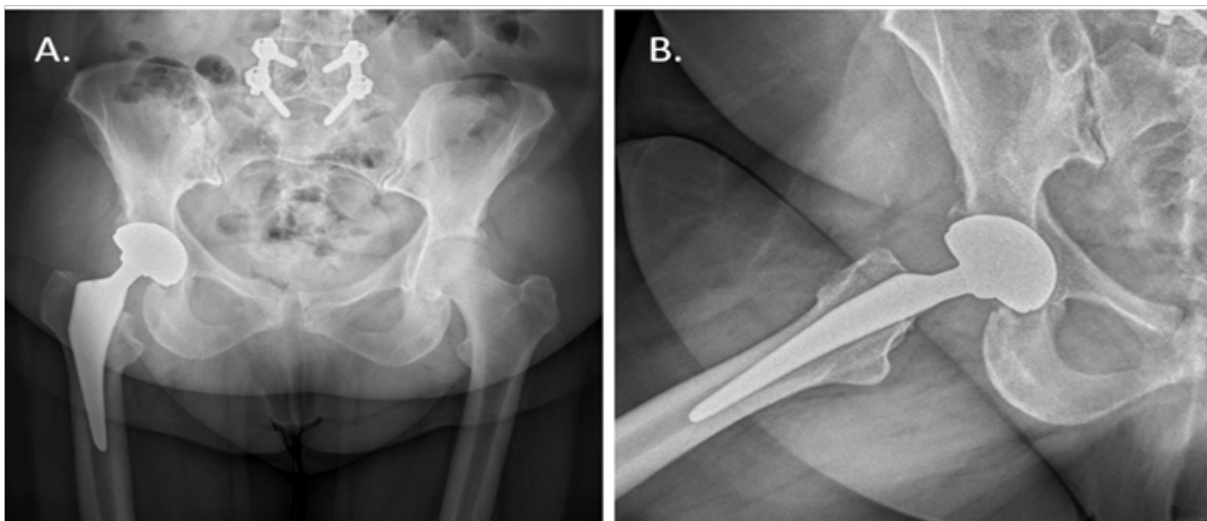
(A) Anteroposterior pelvic radiograph and (B) axial radiograph of the right hip, showing appropriate positioning of the acetabular cup and femoral stem.
